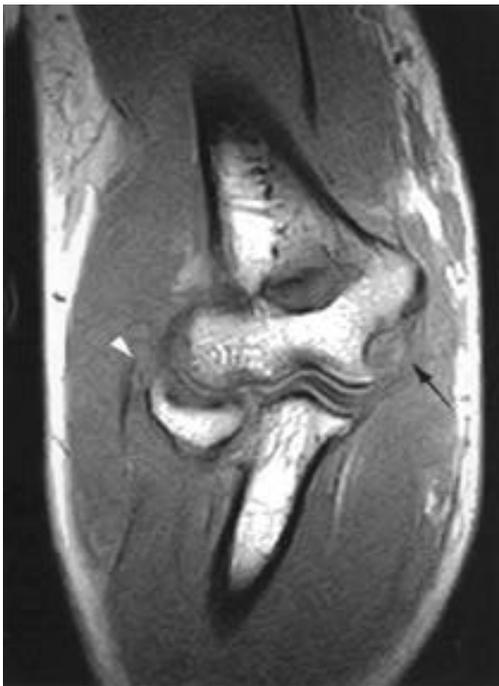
T1-weighted coronal MRI reveals that the medial collateral ligament (arrow) and the lateral collateral ligament (arrow head) were injured, but the bony structures were preserved.
